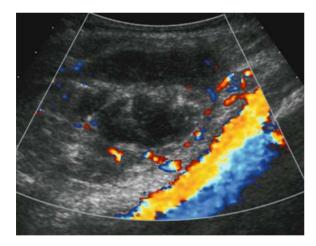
Ultrasound of a heterogenous appendix mass in a 12-year-old girl
